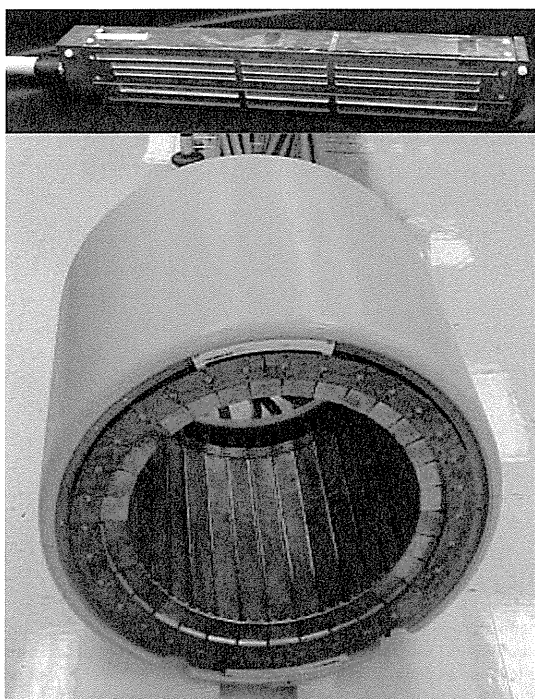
A view of the interior of the BrainPET insert constructed as a ring of 32 individual cassettes. The BrainPET insert fits into the bore of the magnet of the MRI scanner and is positioned at the isocentre. Each cassette contains six detector modules in a row with a total length of 19.2 cm located towards the front end of the cylinder. Each cassette is individually radiofrequency shielded with a thin copper coating; this is to prevent RF noise generated by the PET electronics from disturbing the MRI signal and to reduce the influence of the MRI-related RF and gradient pulses on the PET system. The cassettes are connected to the MR filter plate by a 10 m, double-shielded cable.
